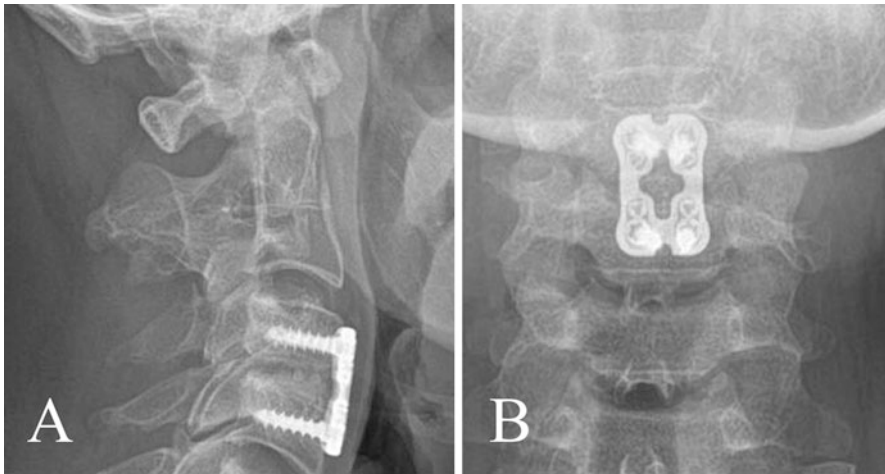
Post-operative imaging. (a) Lateral X-ray following C3–C4 ACDF. (b) AP X-ray
